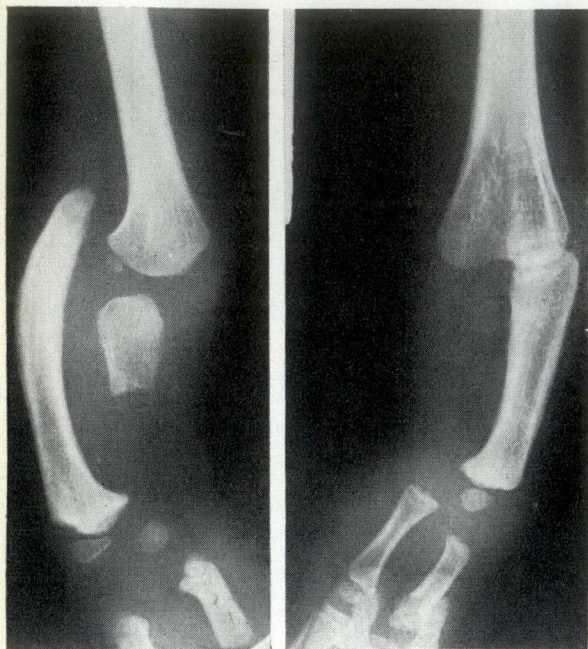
Radiographs at age six years now reveal bilateral *incomplete* absence of ulna; Type 2 on right, i.e., proximal dislocation of head of radius; Type 3 on left, i.e., radiohumeral synostosis.
